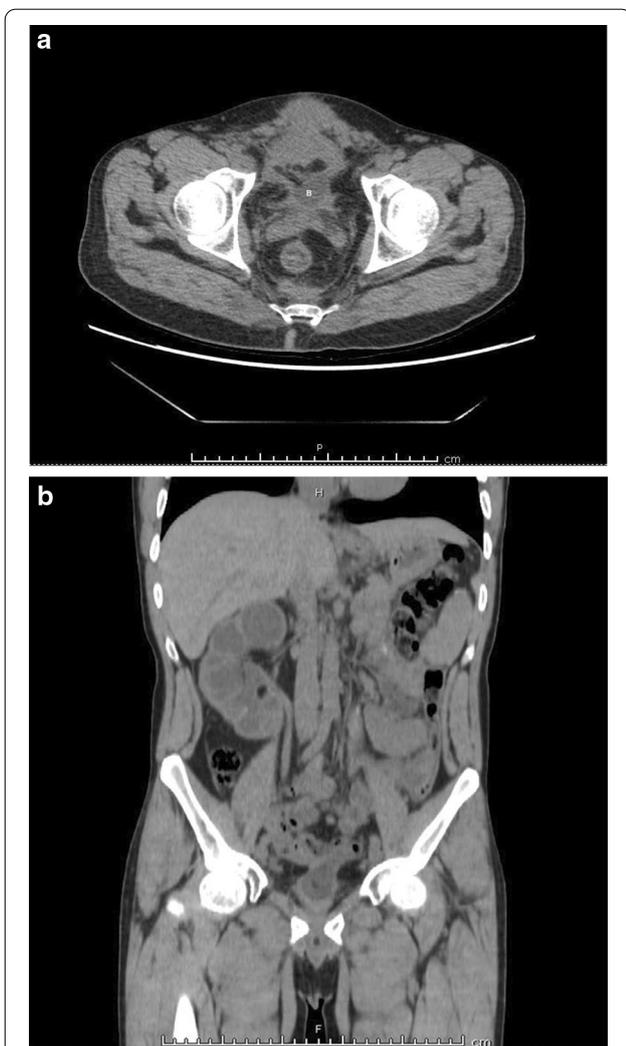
Non-contrast computed tomography images. a Axial cut showing the shrunken small bladder filled by the Foleys balloon. b Coronal cut showing the grossly hydronephrotic right kidney with multiple dilated calyces due to multiple infundibular stenosis and small shrunken pelvis
